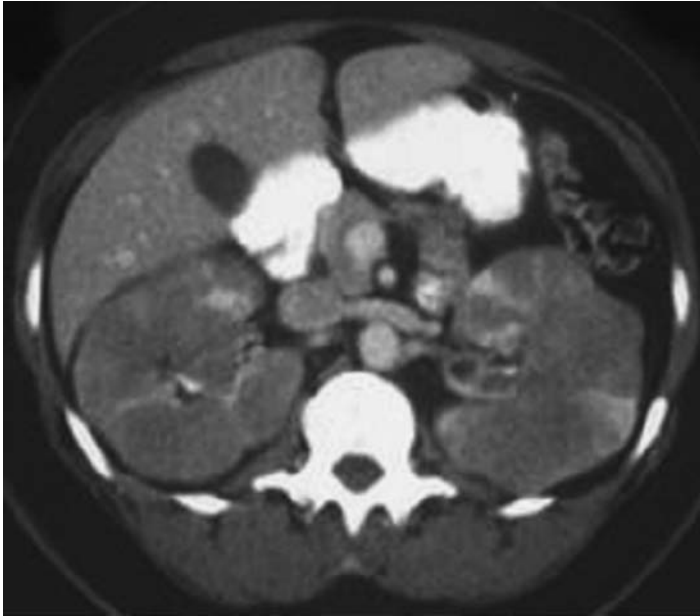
Contrast-enhanced CT demonstrating multiple bilateral poorly enhancing renal masses. The normal renal parenchyma is seen as areas of higher attenuation between the low attenuation masses. Also note that despite the multiple masses the kidneys retain a normal reniform configuration typical of lymphomatous renal involvement.
